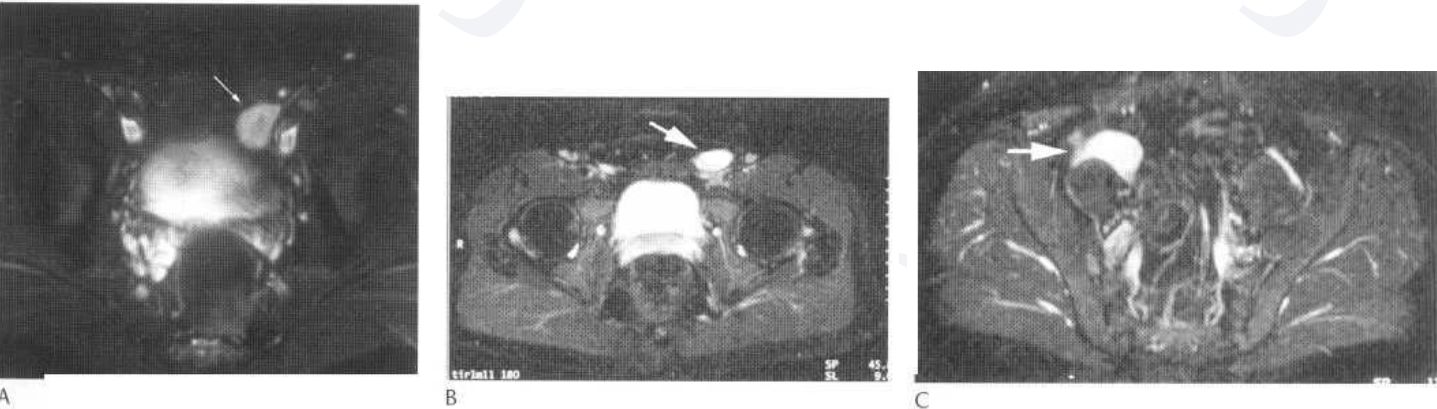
Transverse STIR images from MRI examinations of patients with undescended testicles (arrow) in the proximal end of the inguinal canal (A), suprapubic pouch (B) and pelvis (C).
